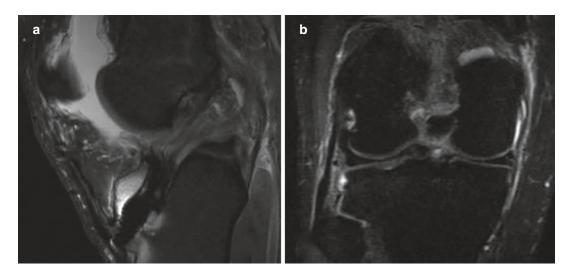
(a) Sagittal MRI (b) Coronal MRI cuts of ACL graft failure
